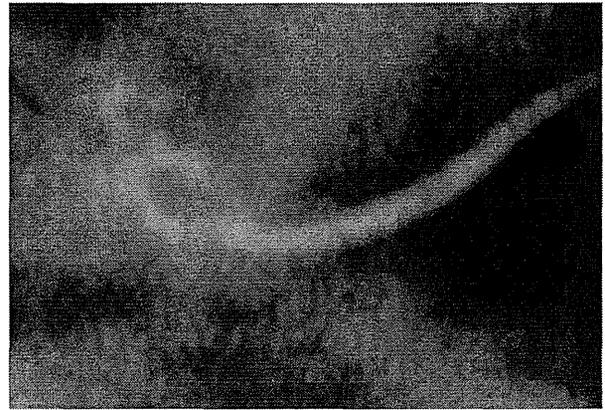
The X-ray of inserted electrode of case 2.
